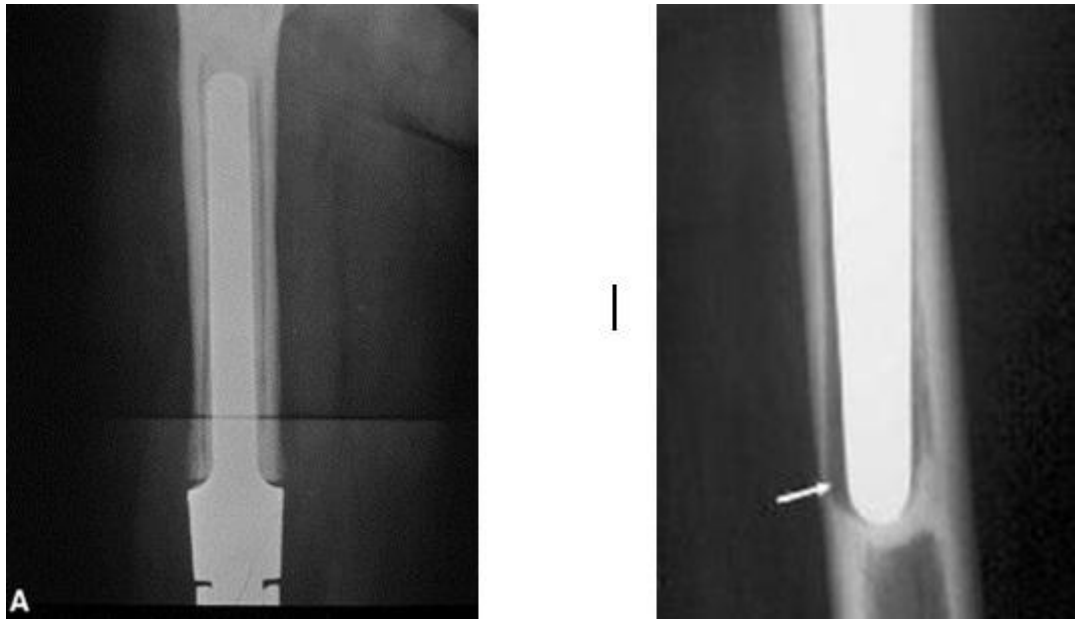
Line on X-ray: aseptic loosening of prosthesis pins.
